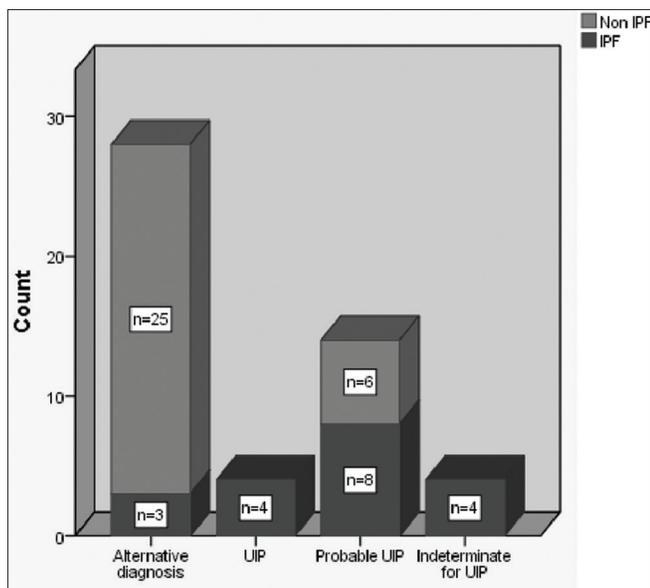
Final diagnosis of IPF according to HRCT patterns. IPF: Idiopathic pulmonary fibrosis, UIP: Usual interstitial pneumonia, HRCT: High-resolution computed tomography
